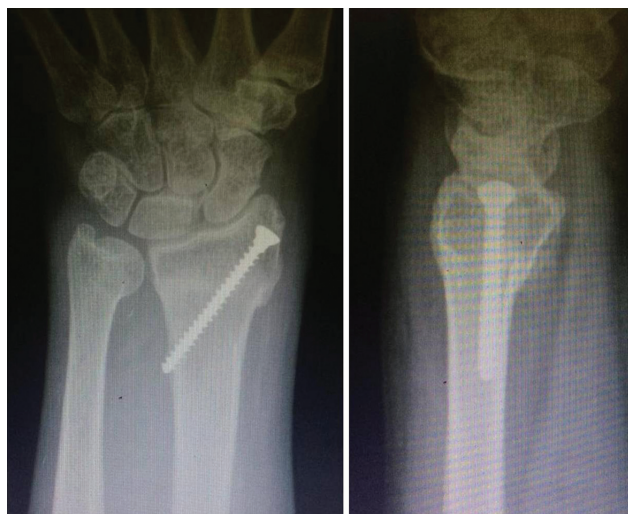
Anteroposterior (AP) and lateral (L) radiographs for postoperative outpatient control of an apparently consolidated fracture treated according to the presented technique.
